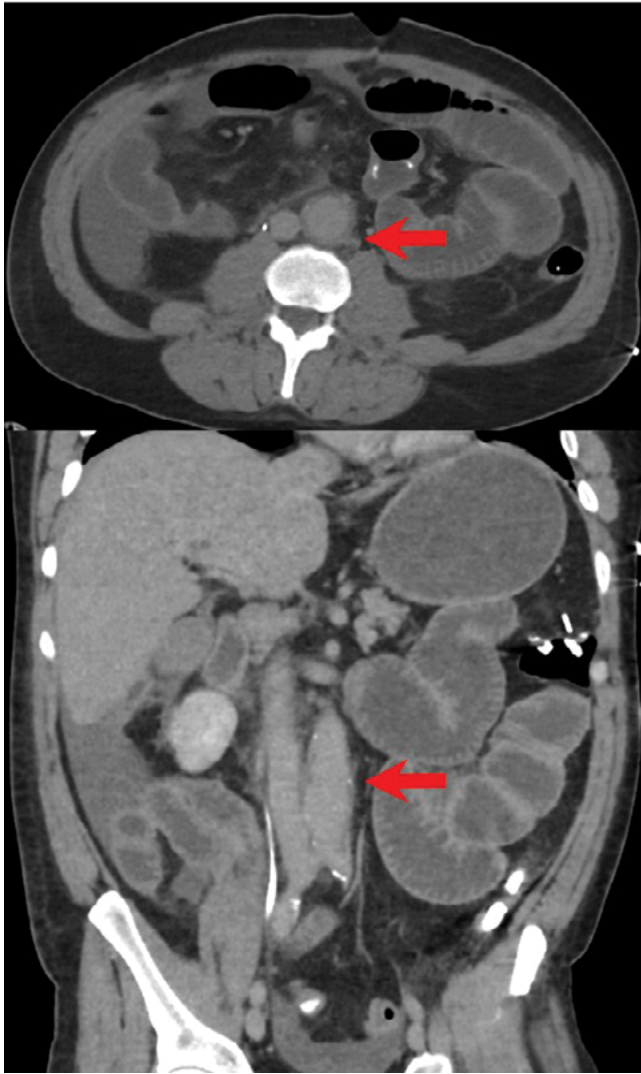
Computed tomography scan on postoperative day 6 in cross-sectional and coronal views showing mild stranding around the aorta (arrows).
